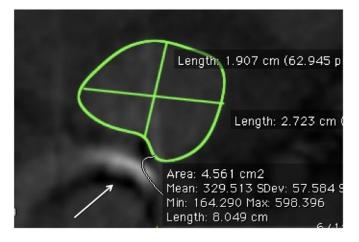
'Cardiac computed tomography based assessment of the aortic annulus'. Asymmetric aortic annulus of 19x27 mm of dimensions and area of 456 mm2. The arrow points an indentation in the aortic annulus caused by the ring of the mitral ballcage prosthesis.
